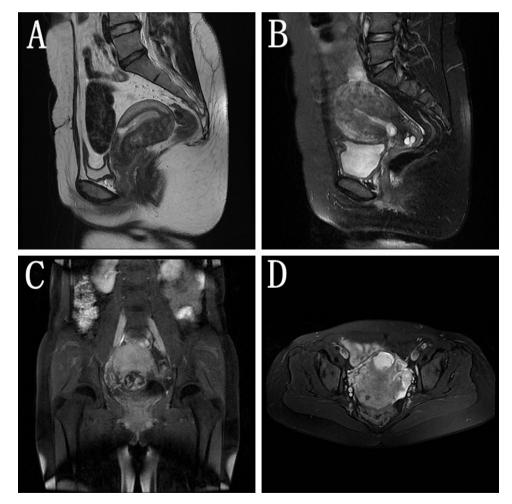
A~D MRI images of cesarean scar pregnancy.
